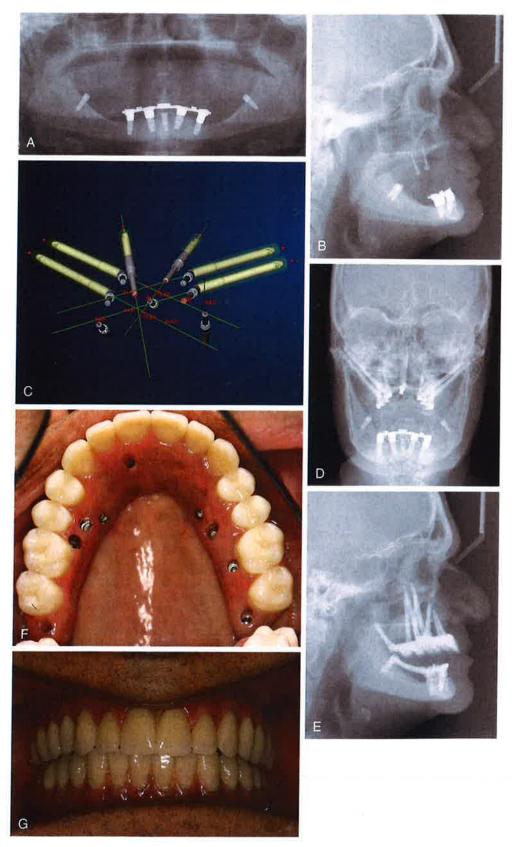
A, Preoperative panoramic radiograph demonstrating severe maxillary bone atrophy. B, Preoperative lateral cephalometric radiograph showing extreme maxillary bone loss. C, NobelGuide Procera software from prior CT scans shows planned implant positions only, including four zygomatic fixtures. D, Postoperative cephalometric radiographs demonstrating traditional and zygomatic placed implant fixtures. E, Occlusal view of maxillary definitive fixed screw-retained titanium and ceramic prosthesis. F and G, Final maxillary and mandibular implant-supported prostheses following the No Bone Solution protocol with no bone grafting required.
